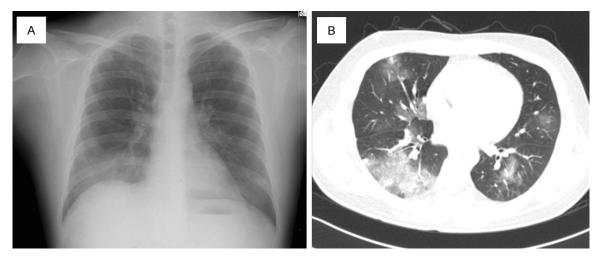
A. Chest X-ray at the time of admission showed pneumonia in whole lung. B. CT showed multiple nodules and diffused ground glass opacities in both lung fields.
